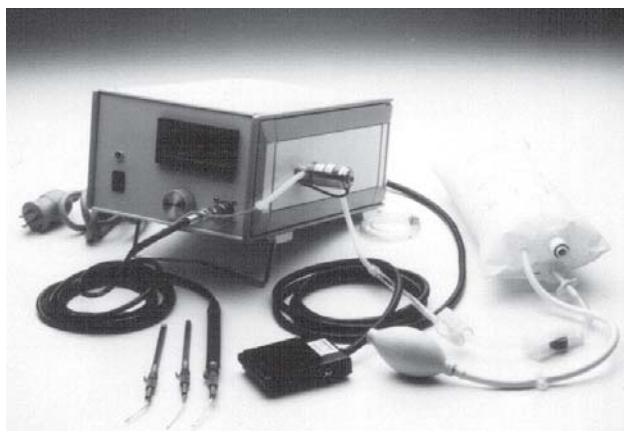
King Ultrasonic Endarterectomy (KUE) device
